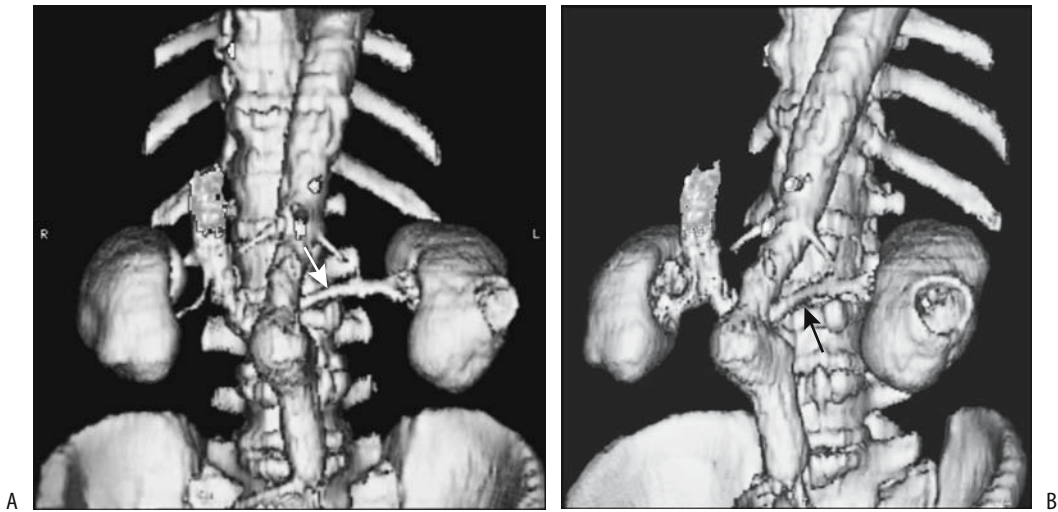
Retroaortic left renal vein. Frontal (A) and oblique (B) 3D CT reconstructions reveal the left renal vein (arrows) posterior to a tortuous aorta. (Courtesy of Patrick Fultz, M.D., University of Rochester.)
